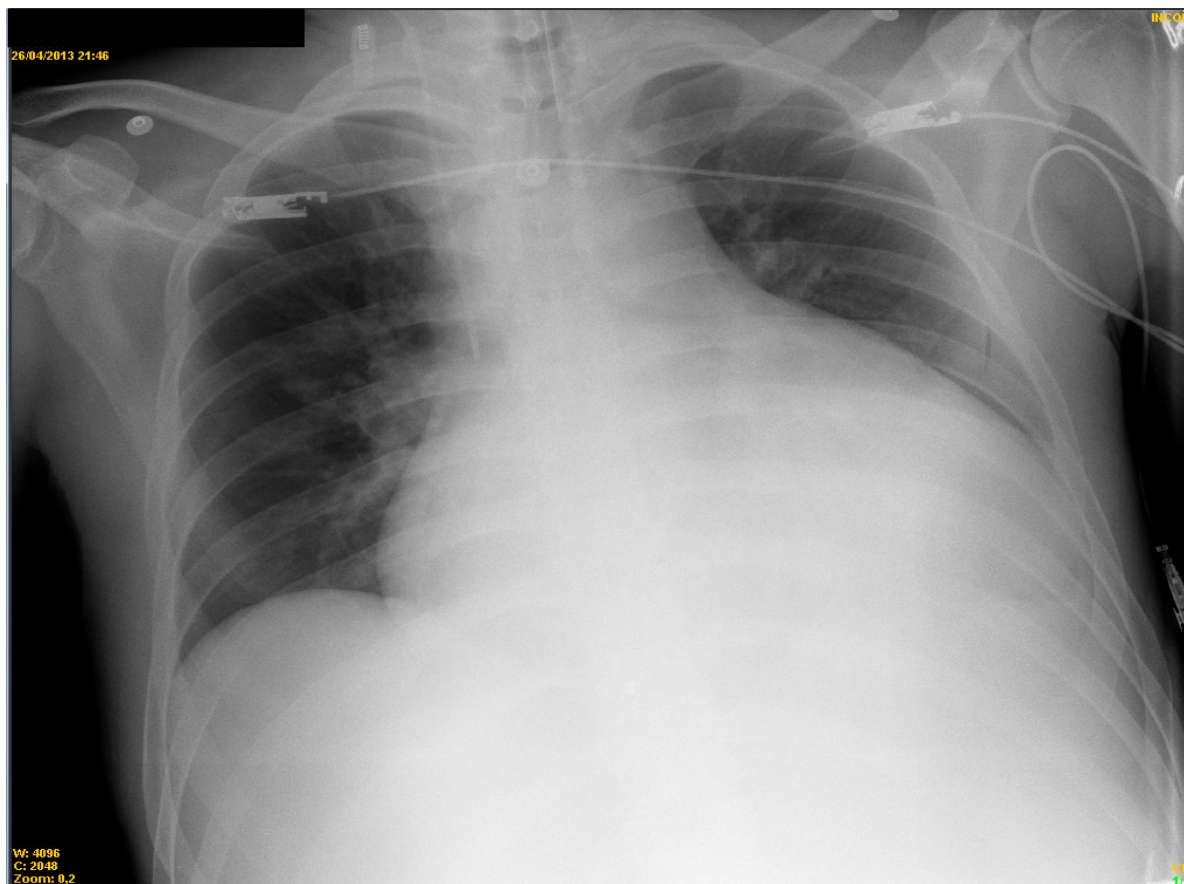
Chest X-ray (anteroposterior - bed). Marked cardiomegaly and free pulmonary fields.
